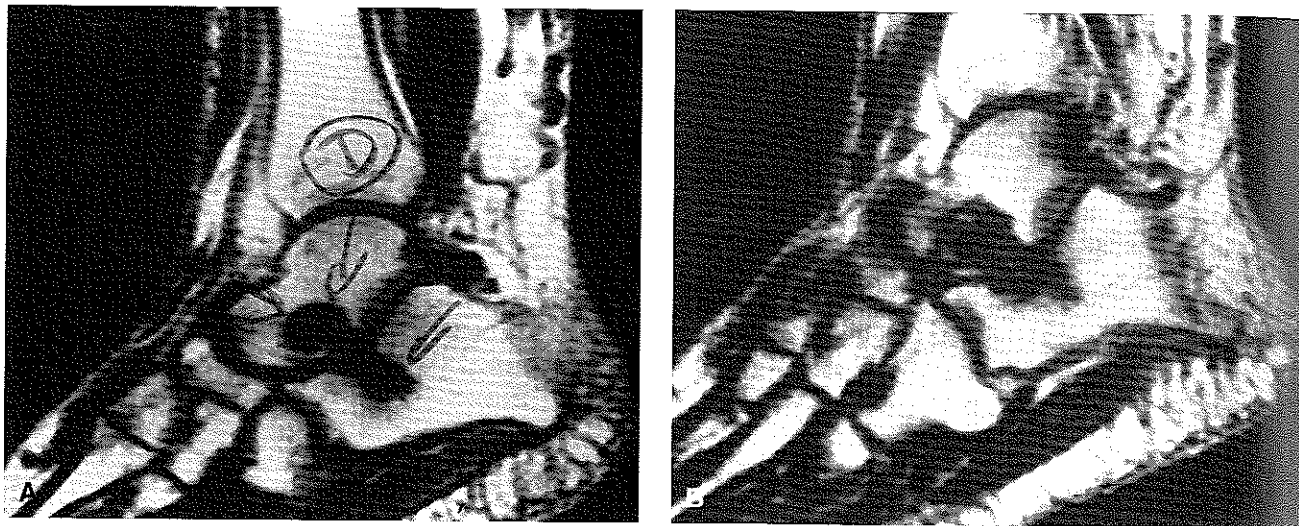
A: This T1-weighted magnetic resonance imaging scan shows extensive changes within the sinus tarsi labeled *D*. Normal fat signal intensity of the sinus tarsi is replaced by tissue of low signal intensity. Decreased signal intensity is noted, obliterating the interosseous talocalcaneal ligament on this image. Additionally, significant subcortical erosion is identified within the critical angle of Gissane and the posterior subtalar joint facet. B: This demonstrates the interosseous ligament and subcortical erosions within the critical angle of Gissane. These findings, low signal intensity on both T1-weighted and T2-weighted images, indicate fibrotic changes within the sinus tarsi.
